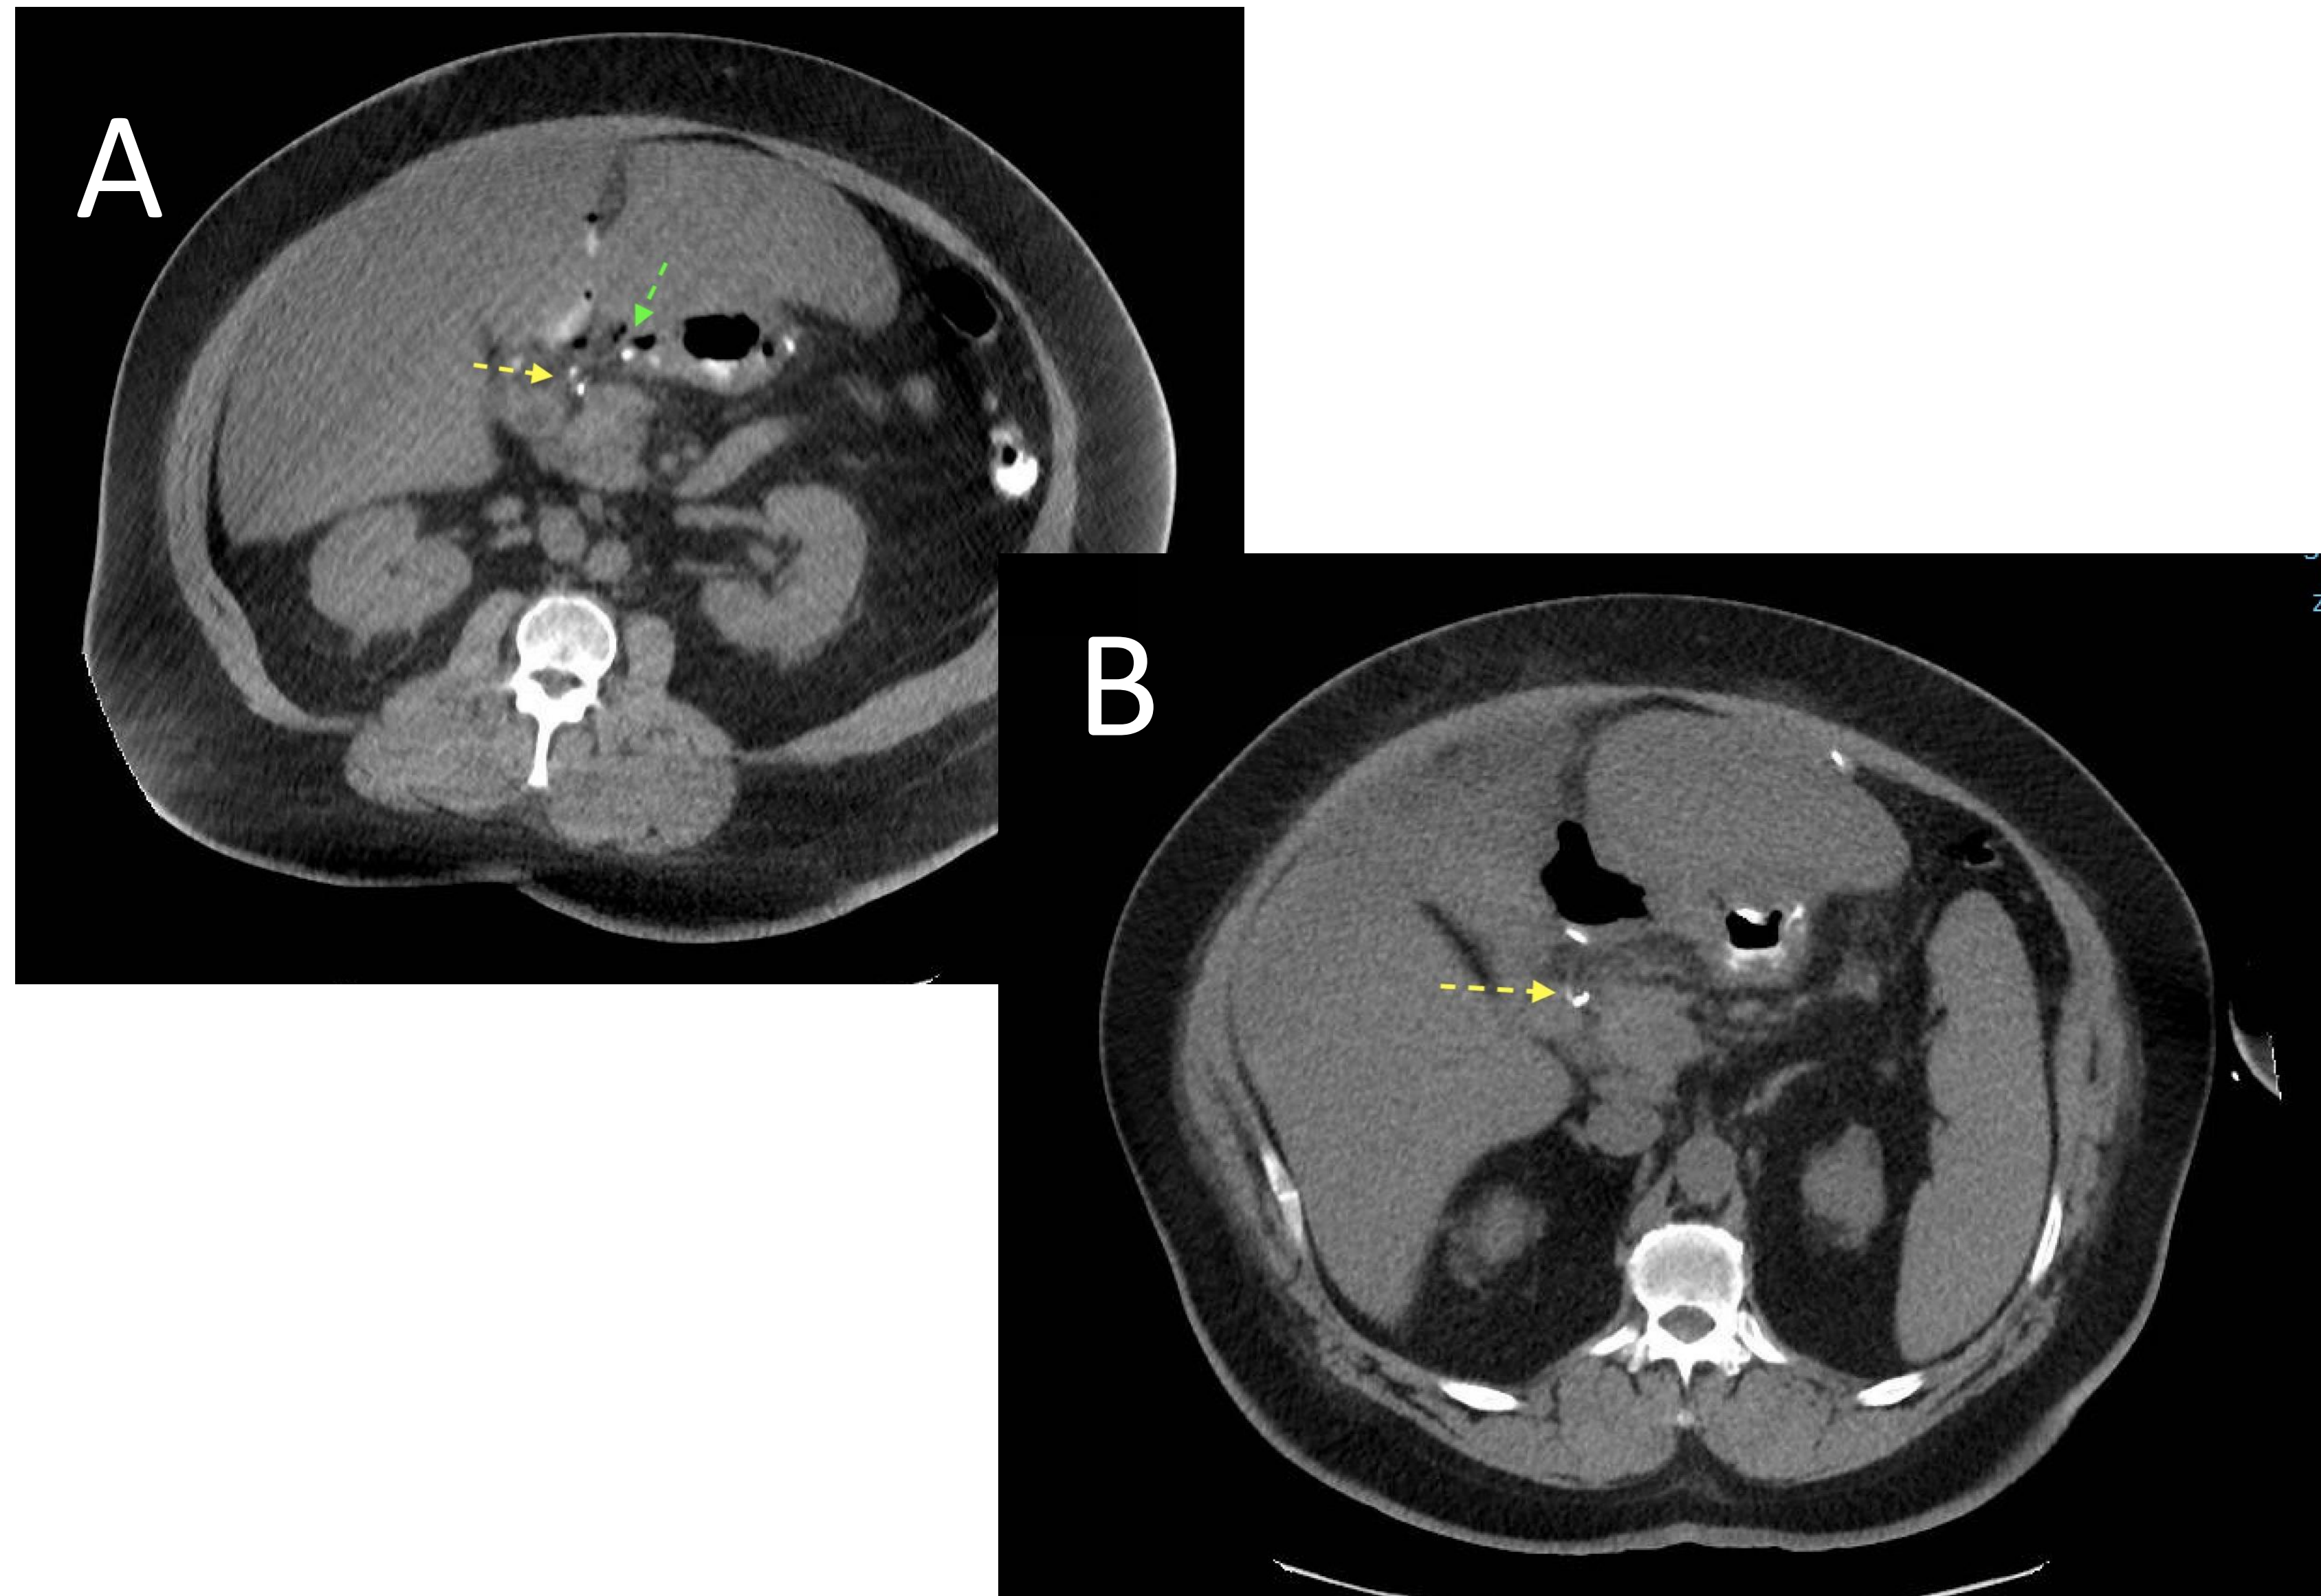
A) Initial CT scan with leak demonstrating extravasation of enteric contrast. Additionally, duodenal stump and duodenal cuff staple lines are seen on the same axial plane. B) Repeat CT scan demonstrating adequate mobilization of the duodenum. The duodenal cuff is 2.25cm caudal to the duodenal stump after second operation. Yellow arrow, duodenal stump; green arrow, duodenal cuff.
